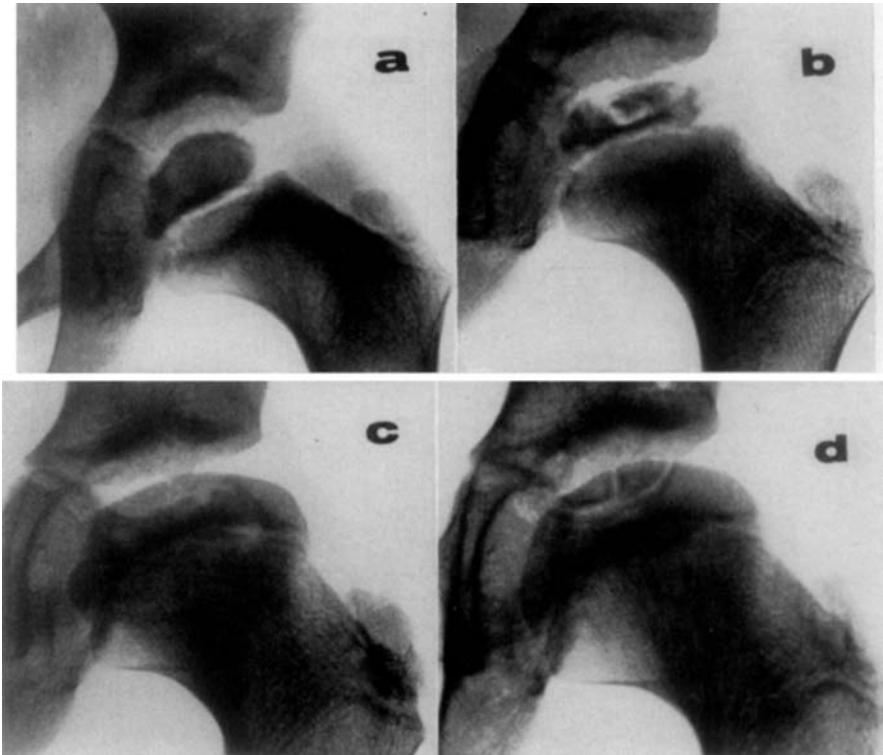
Case 229, boy aged 6 years and 6 months at onset. The radiographs *a—d* show the development of osteochondrosis dissecans.
